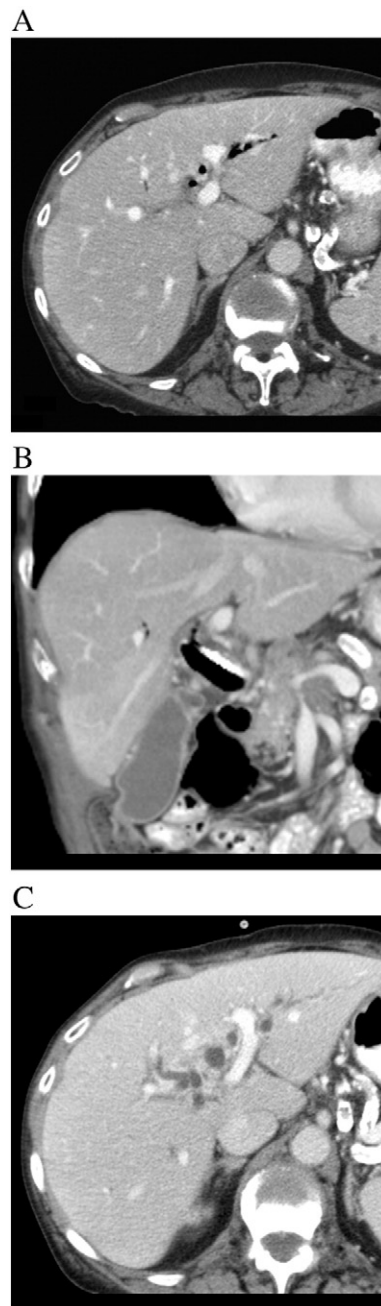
A 77-year-old woman with biliary stricture from pancreatic adenocarcinoma. (A) Axial and (B) coronal contrast-enhanced CT shows intrahepatic pneumobilia with plastic stent in common bile duct. (C) Follow-up CT shows resolution of intrahepatic pneumobilia. Stent occlusion was found at ERCP due to tumor ingrowth.
